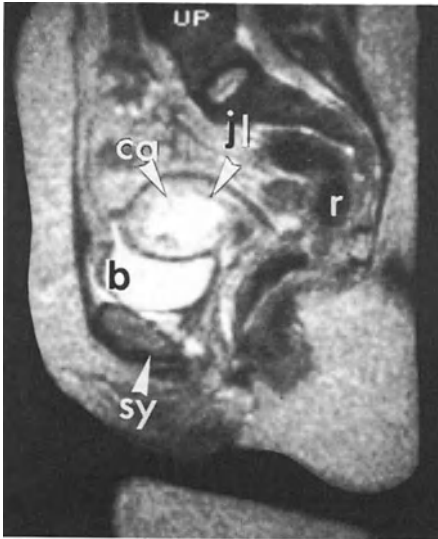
MRI: infiltrating carcinoma of endometrium. Typical irregular appearance of the carcinoma (*ca*). Destruction of the junction line (*jl*) in the fundus. *b*, bladder; *r*, rectum; *sy*, symphysis
